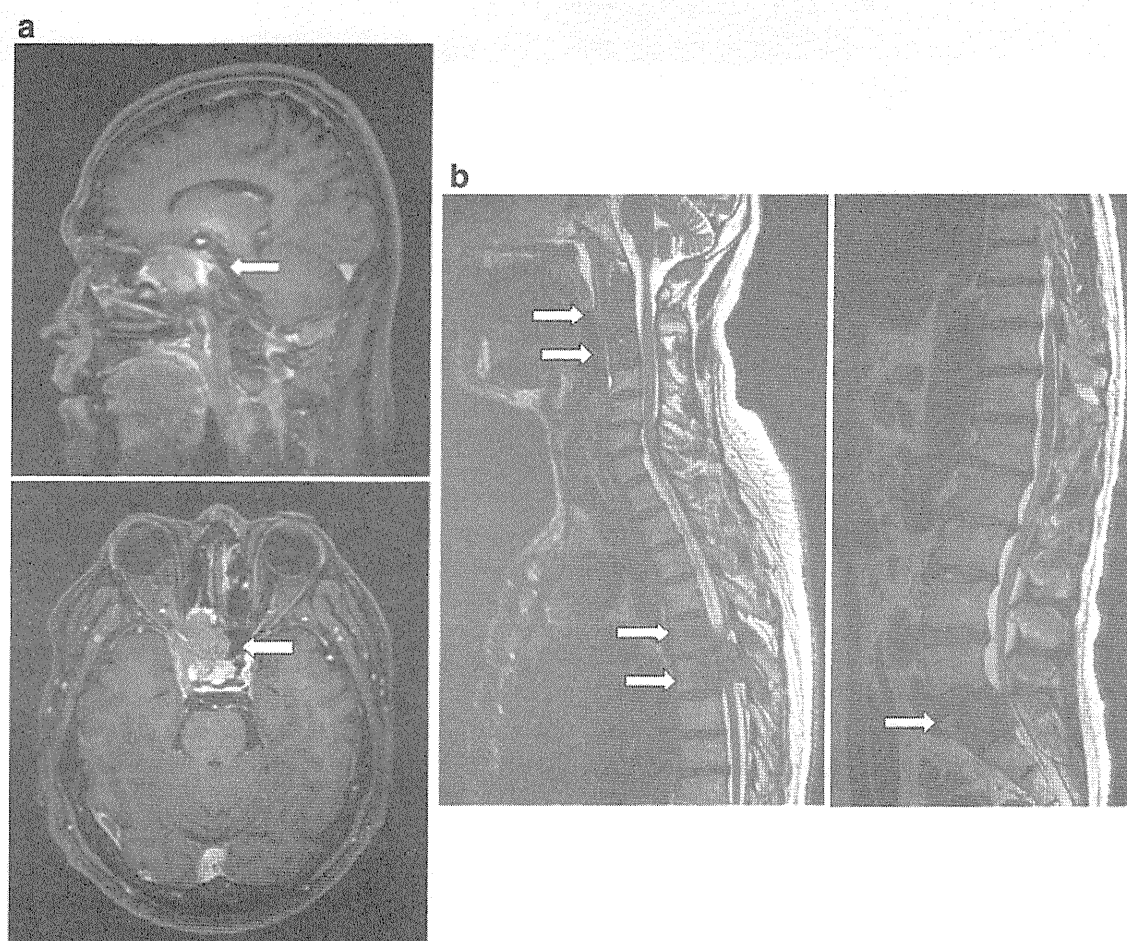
Cranial and spinal magnetic resonance imaging (MRI) on admission. a Enhanced cranial MRI, T1-weighted image. b Spinal MRI, T2-weighted image. Arrows indicate the mass in each image
